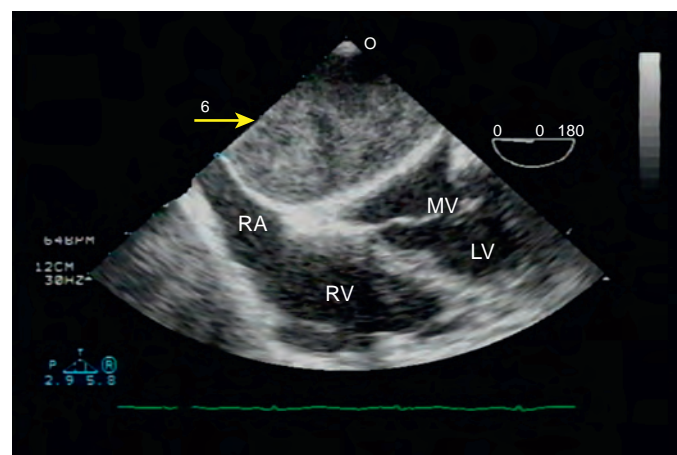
Initial intraoperative midesophageal four-chamber transesophageal echocardiographic view at 0 degrees of the heart. Patient with a posterior mediastinal tumor that was compressing the left atrium, showing near complete compression of left atrium by the tumor (yellow arrow) posteriorly and also compression of the right atrium (RA). Although the left atrium was severely compressed by the tumor (a mediastinal Schwannoma), there is no clear evidence that the tumor extends through the wall of the atrium. MV, mitral valve; LV, left ventricle; RV, right ventricle.
